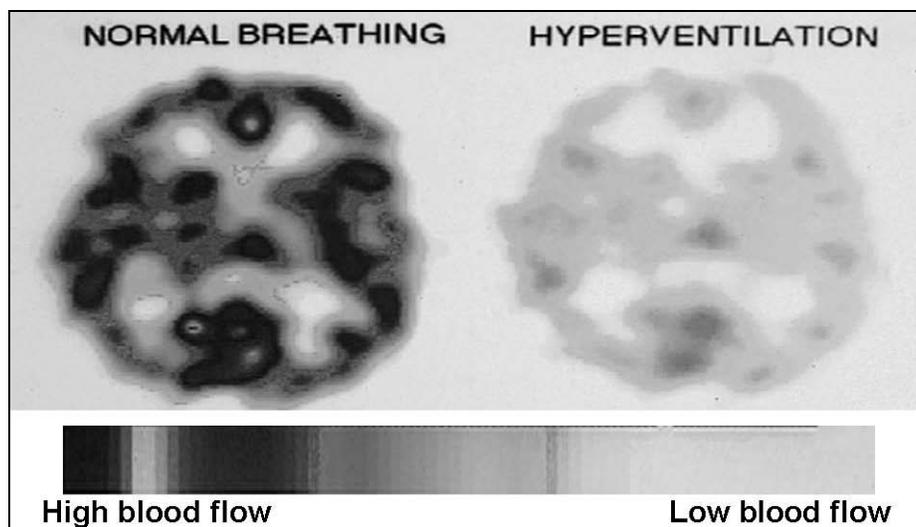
Blood flow through the brain in healthy subjects as measured with single photon emission computed tomography (SPECT) by looking at the brain from above during normal breathing and hyperventilation. The darker color indicates increased blood flow. During hyperventilation ($PCO_2 < 20$ torr) there was a significant decrease in blood flow throughout the brain. By permission from Scott Woods, M.D., Yale University, unpublished data, 1987. (For detailed methodology see, Wallace et al, 1996)
